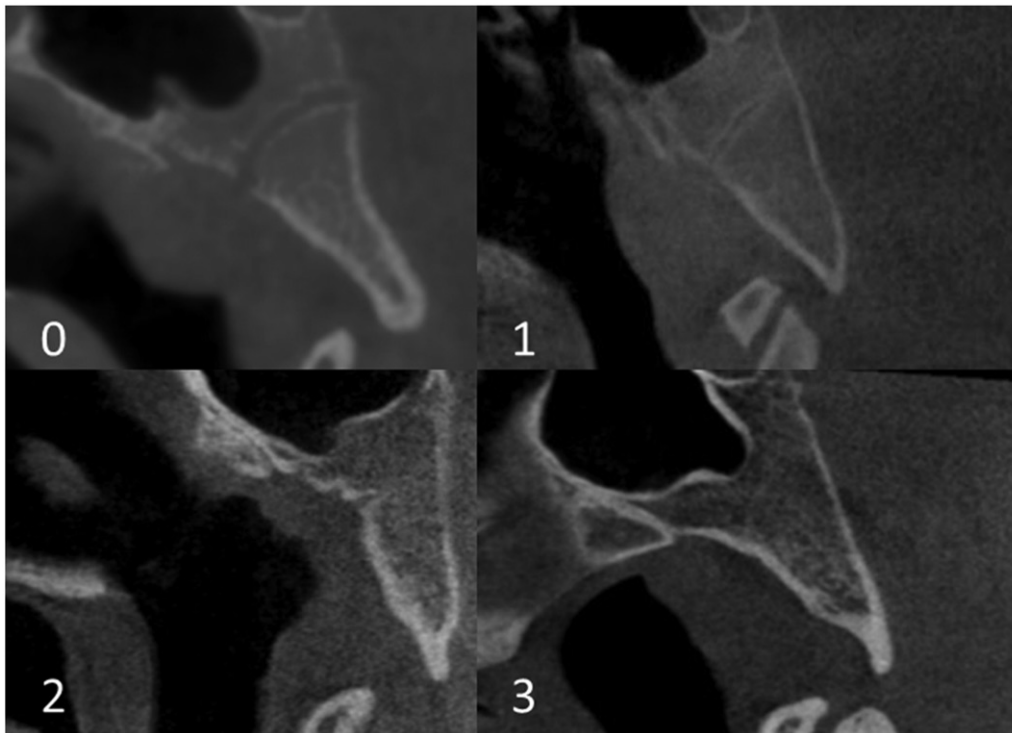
Mid-sagittal CBCT images demonstrating spheno-occipital synchondrosis fusion stages. Stage 0, unfused; Stage 1, fusing endocranially; Stage 2, fusing ectocranially. Stage 3, complete fusion.
